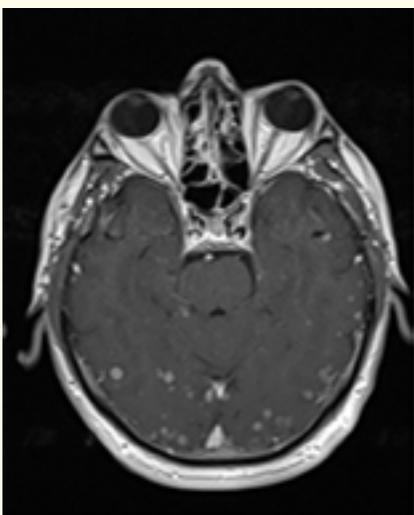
Cranial MRI image.
